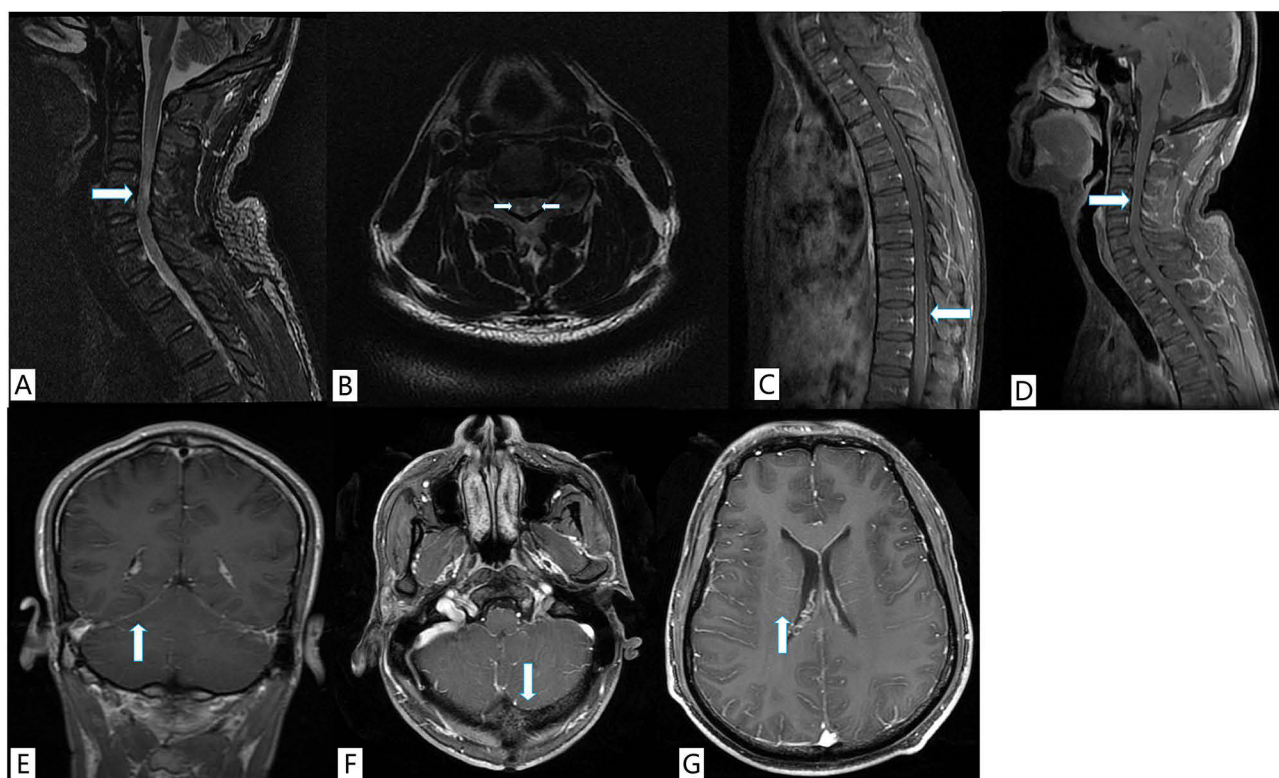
MRI images of the brain and spinal cord of patient #2, a male, 37 years old, with headache, fever, dizziness, vomiting, radicular pain, dysuria, and ataxia. (A and B) Plain MRI images at C4-5 level showing symmetrical strip-like T2 enhancement in the medial posterior region of the spinal cord (arrow); (C and D) Cervical contrast-enhanced MRI images showing abnormal enhancement of signal in pia mater of cervical/thoracic spinal cord (arrow); (E and F) Brain contrast-enhanced MRI images showing multiple enhancement of signal at supratentorial and subtentorial pia mater (arrow); (G) Contrast-enhanced MRI scanning of the brain showing linear enhancement (arrow) beside ventricle (arrow).
